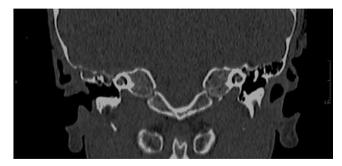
Post-anti-TB treatment temporal bone CT scan of case 2.
